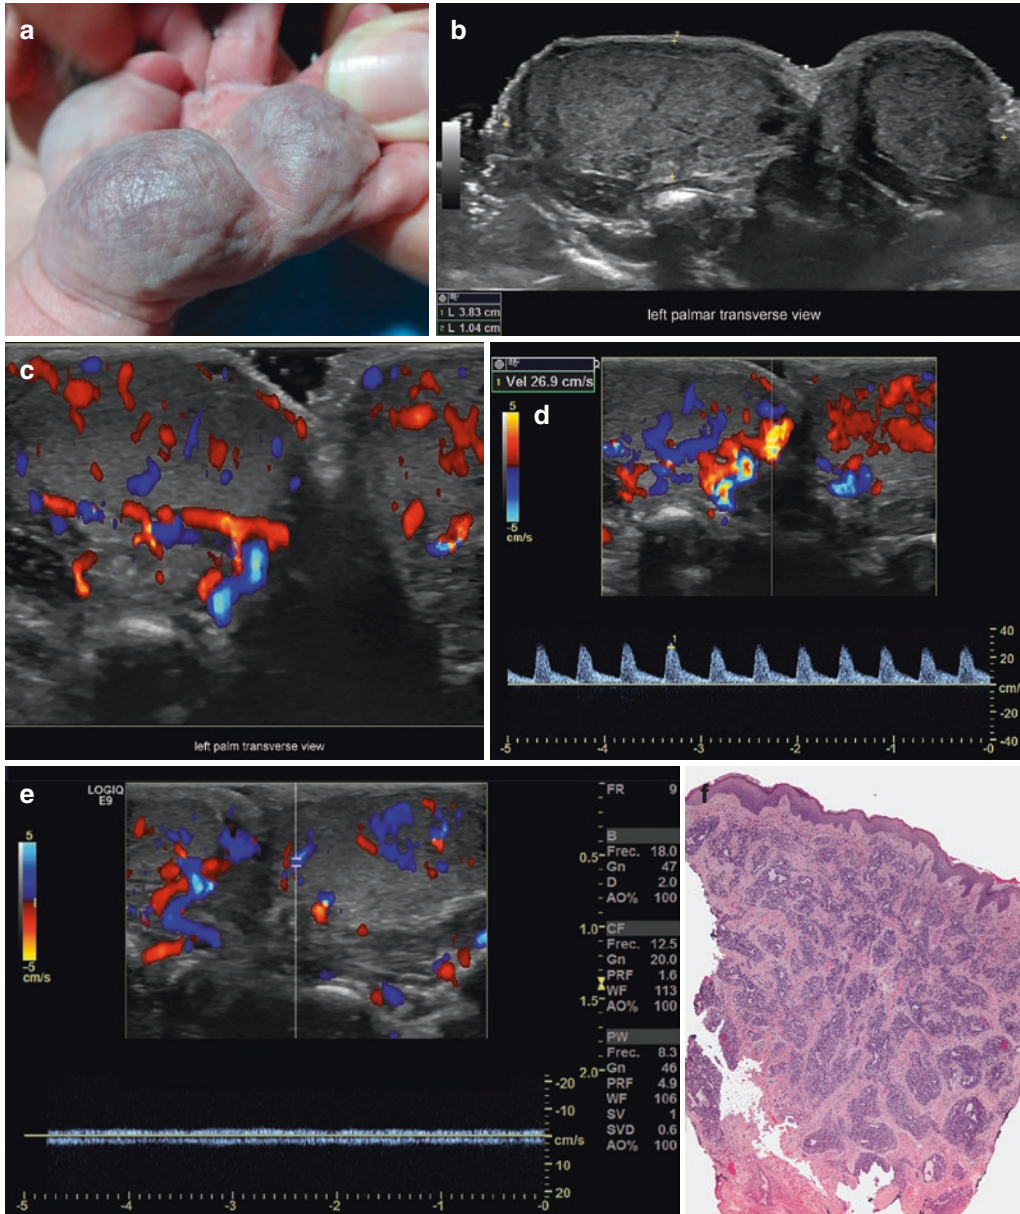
Rapidly involuting congenital hemangioma (RICH). (a) Clinical lesion. (b) Grayscale ultrasound (transverse view) shows a hypoechoic dermal and hypodermal mass with lobulated borders. (c) Color Doppler demonstrates prominent vascularity within the mass.
